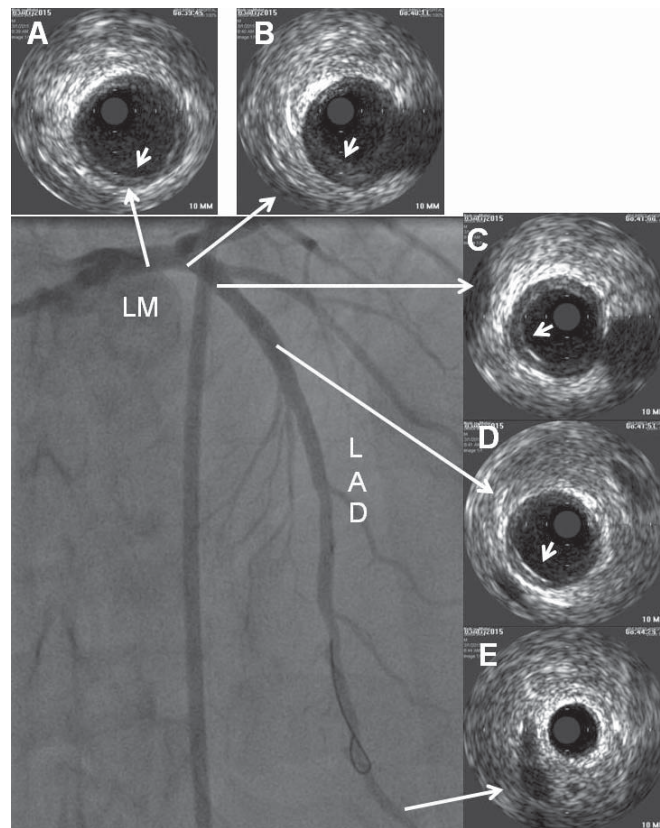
Intracoronary ultrasound sonogram delineated only minimal plaque burden in LM, proximal and mid LAD artery (white arrow, A-D) and no plaque in distal LAD artery (E). LM: left main, LAD: left anterior descending.
